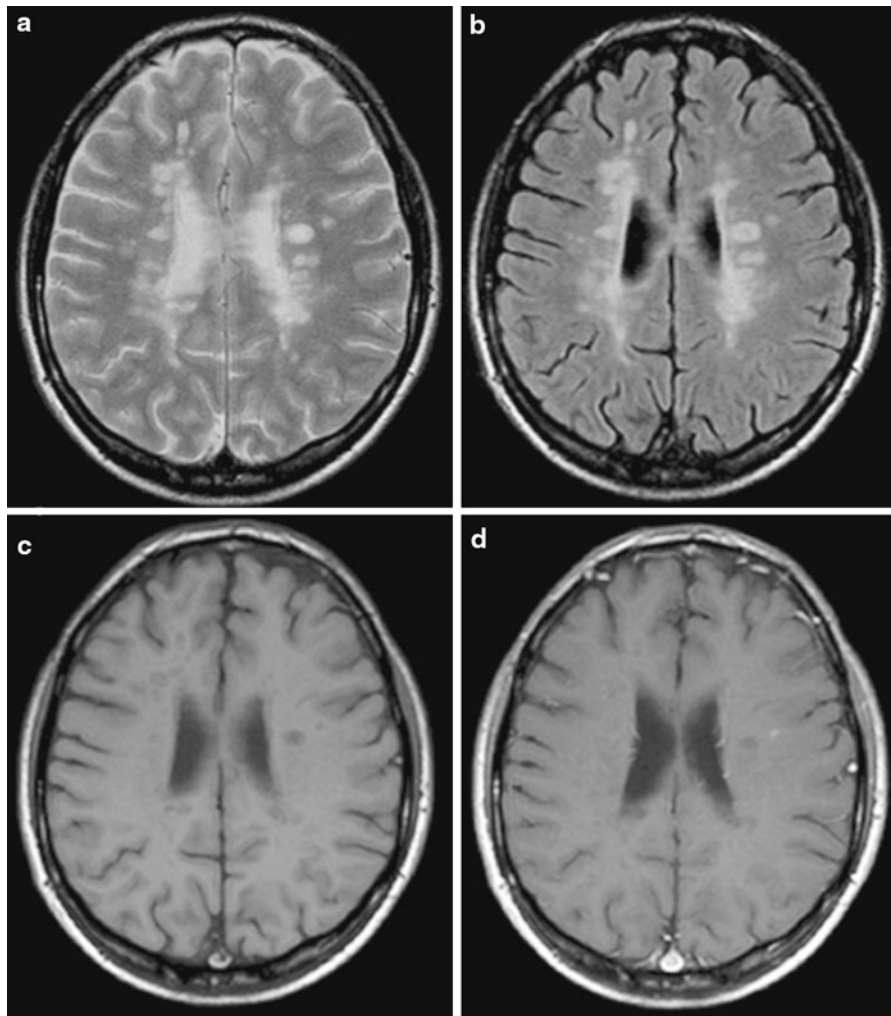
MRI of patient's brain performed in August 2006. a T2-weighted imaging showing grey and white matters and focal lesions; b FLAIR axial cut showing hyperintense signals (lesions); c T1-weighted image showing locations of a-specific
